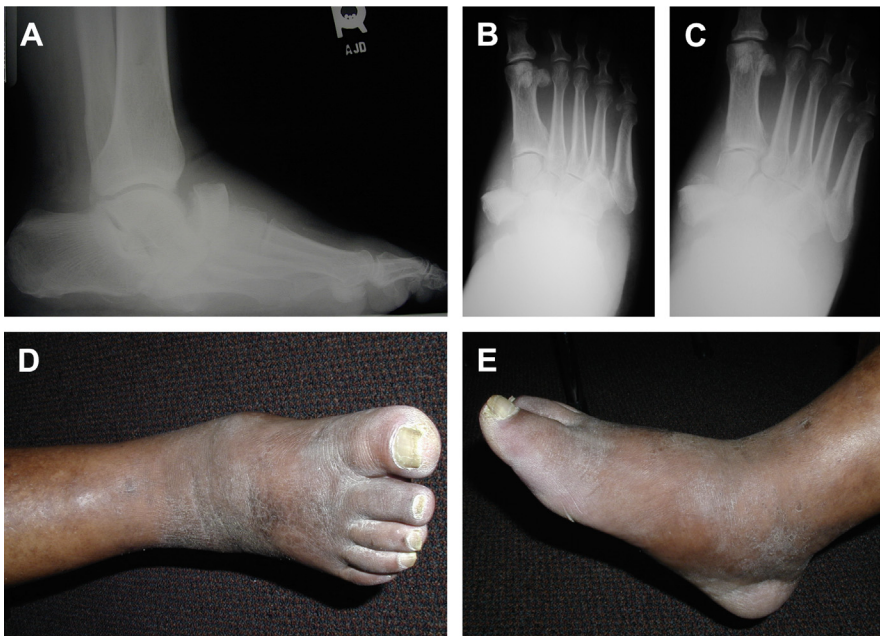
(A–C) Lateral, anteroposterior, and oblique plain film radiographs of a patient with a midfoot CN deformity with a dorsally and medially dislocated navicular without talonavicular joint instability. (D, E) Clinical photographs demonstrate increased redness and pedal edema, consistent with physical examination findings of CN.
